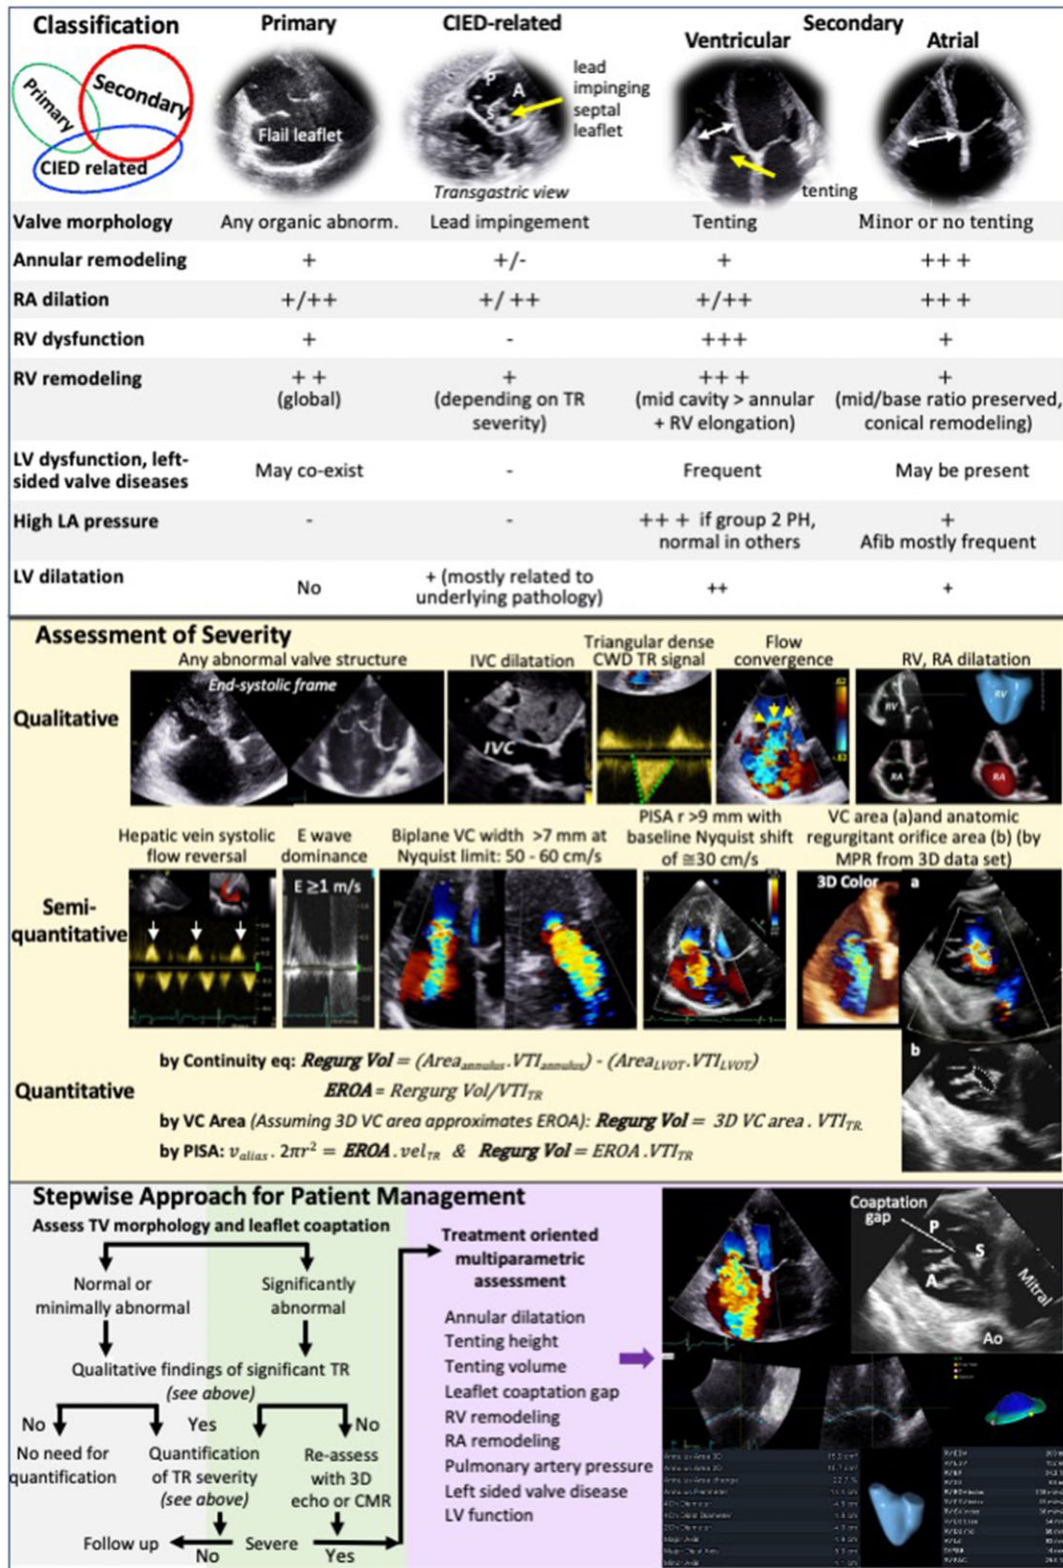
Practical approach for assessing severe TR by echocardiography. A, anterior; Ao, aorta; P, posterior; Pm, pacemaker; S, septal; all other abbreviations as in the text.
